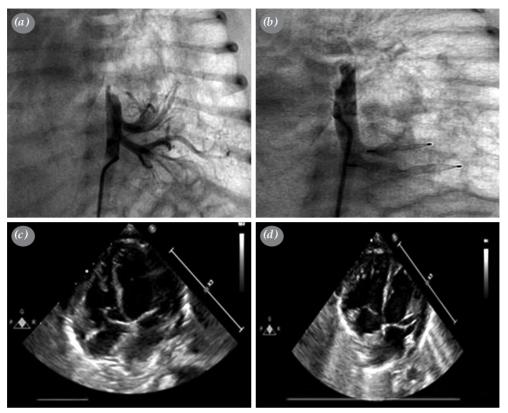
(a) Conventional angiography showed two sequestration artery originated from descending artery. (b) Complete occlusion of the sequestration after vascular plugs. (c) Transthoracic echocardiography in the apical 4-chamber view demonstrating dilation of left heart chambers before the intervention. (d) Regression of left ventricular dilation immediately after intervention.
